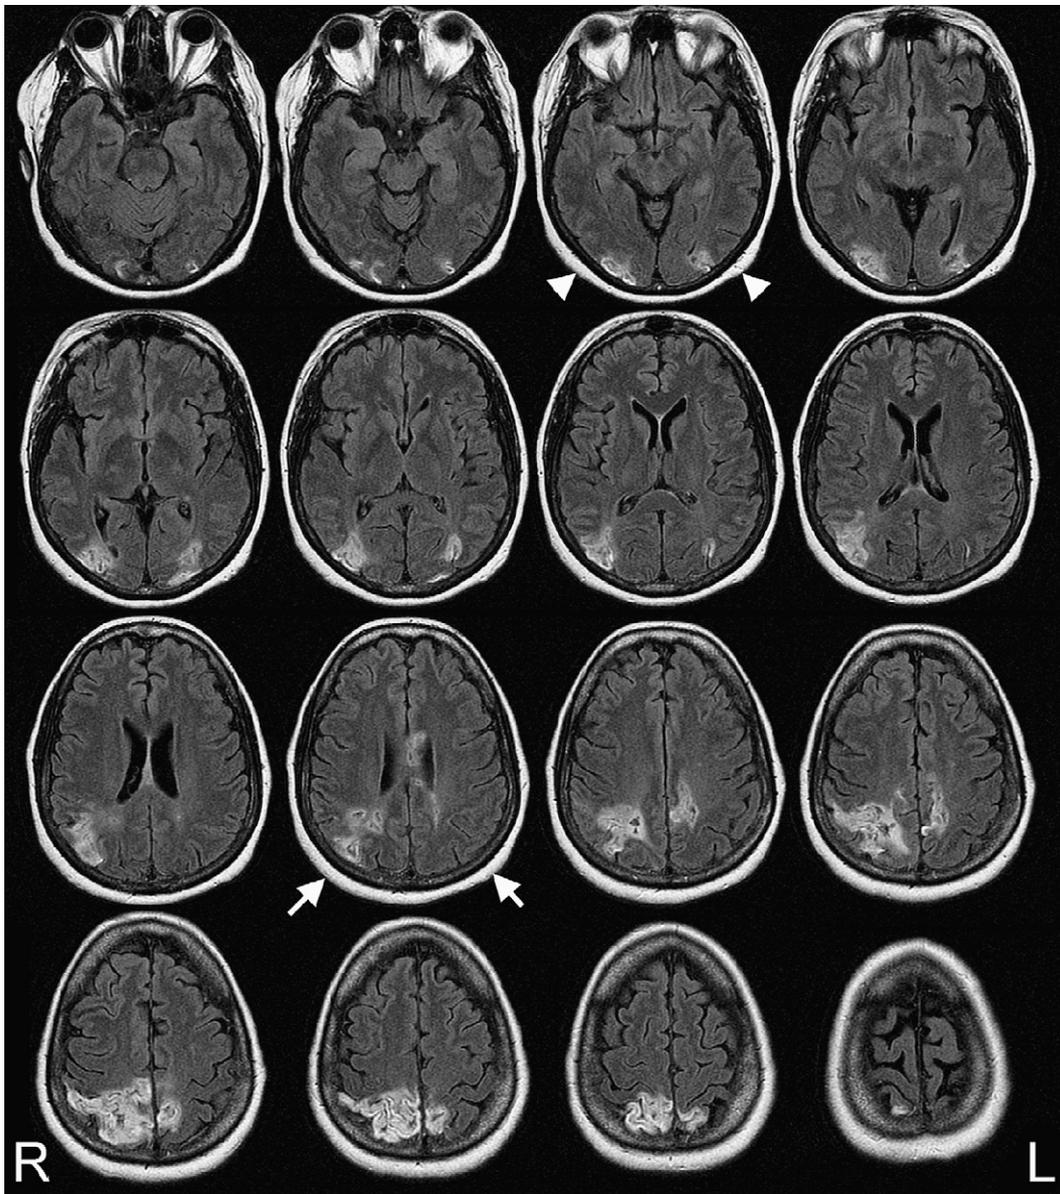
Axial fluid-attenuated inversion recovery (FLAIR) sequences of MRI scans for patient SL. R = Right, L = Left side of the brain. Arrowheads indicate the junction of Brodmann areas 19 and 37, while arrows indicate the junction between areas 39 and 40.
